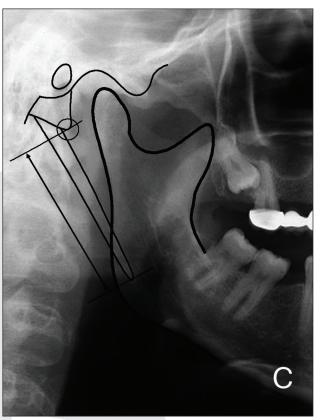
(A,B,C). The styloid process length was measured by using anatomical landmarks on the panoramic radiographs in patients with endstage renal disease. (Based on Jung et al. [8] and Sisman et al. [17])
